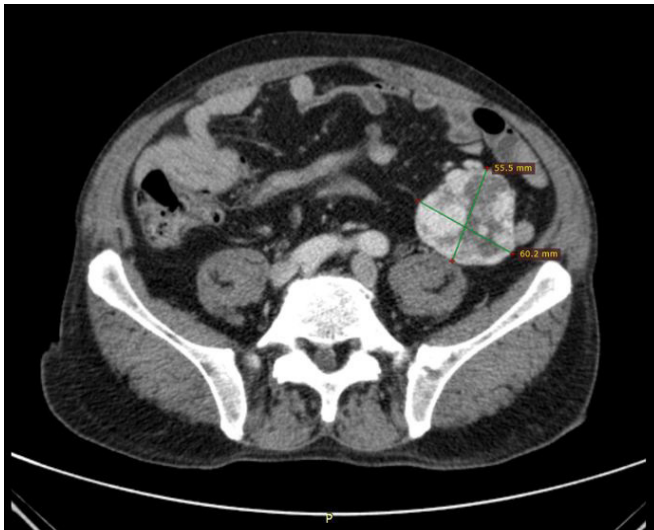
CT demonstrates a well-defined mass situated at the mesentery.
